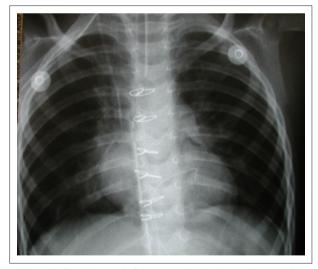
Chest X-ray on the 3rd postoperative day shows a decrease in the right lower arch due to right atrium regression.
